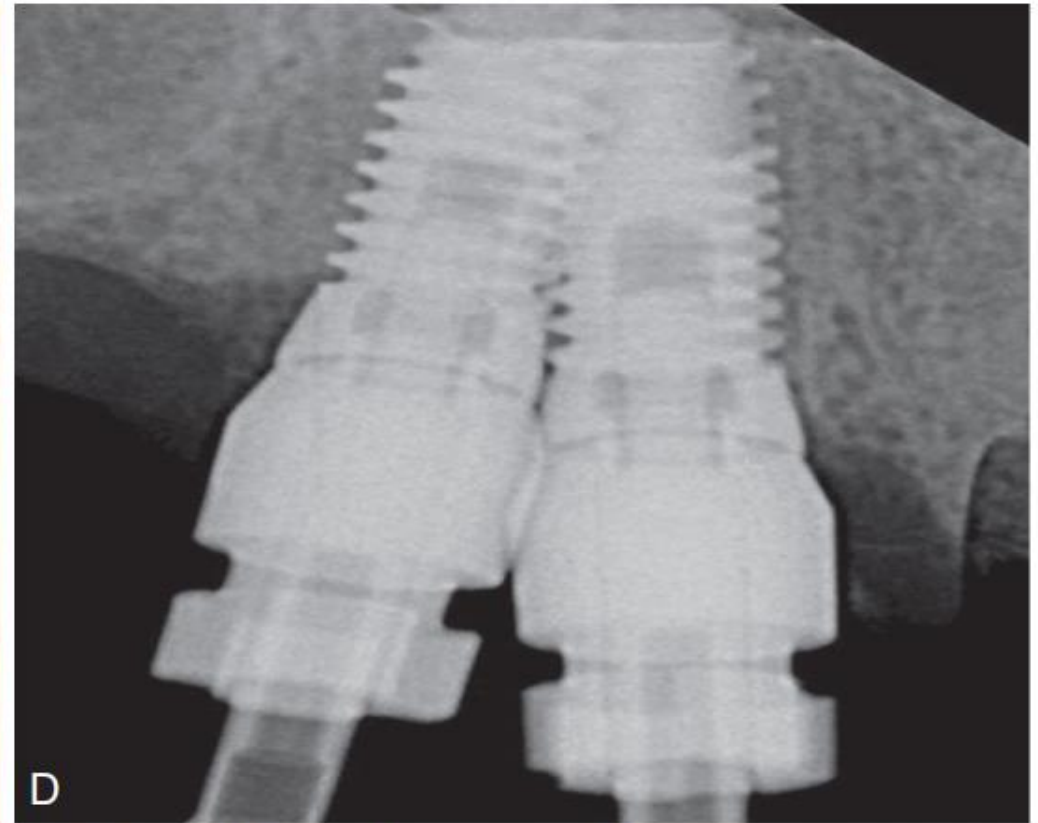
Implant-implant distance. (A) Ideal spacing of 3 mm. (B) Lack of implant-implant distance showing minimal space for prosthesis and maintaining bone health. (C) Lack of space results in difficulty in hygiene with resultant soft tissue complications. (D) When implants are placed too close together, difficulty in obtaining accurate transfer impressions results. In some cases, the transfer impression copings may be altered to obtain final seating. A radiograph confirming the complete seating of the transfer copings should be completed prior to the impression.
